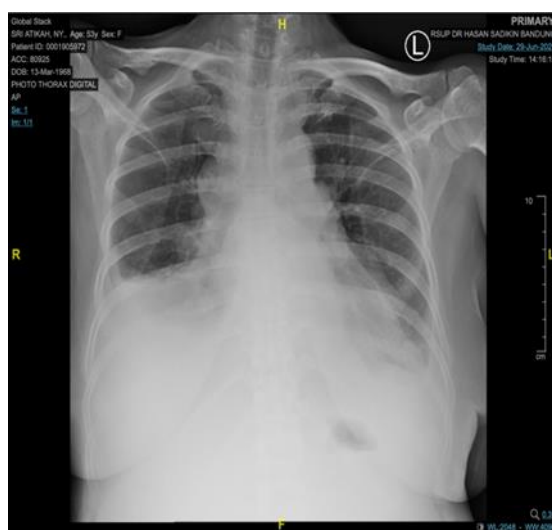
X-ray view of the chest.
